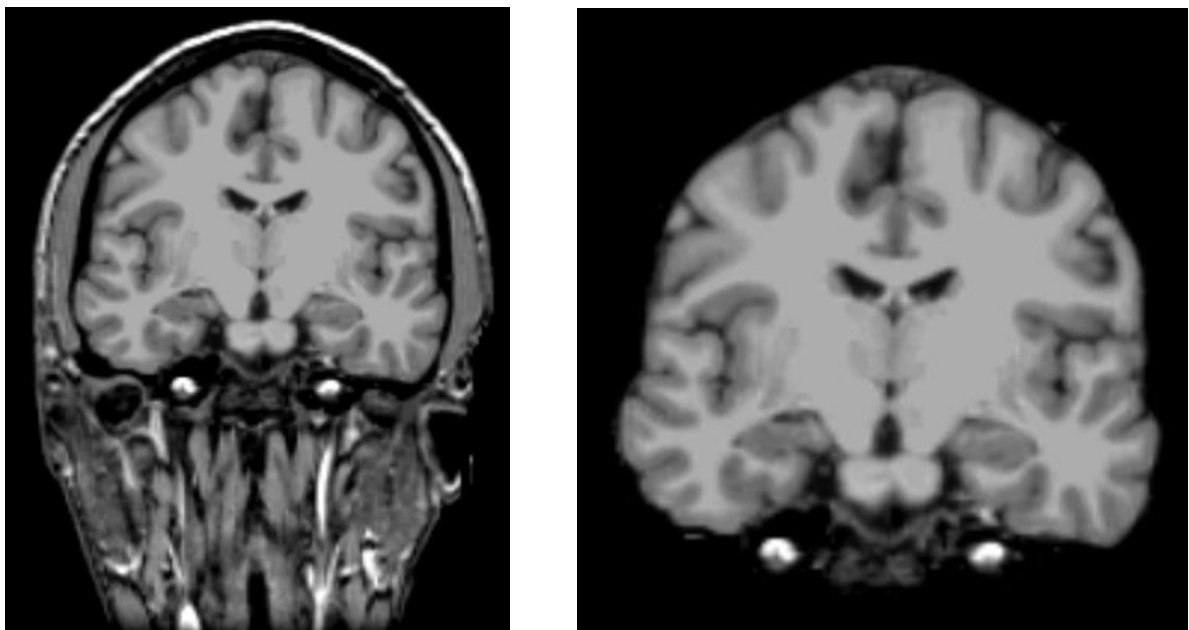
MRI image pre (left) and post (right) skull stripping
